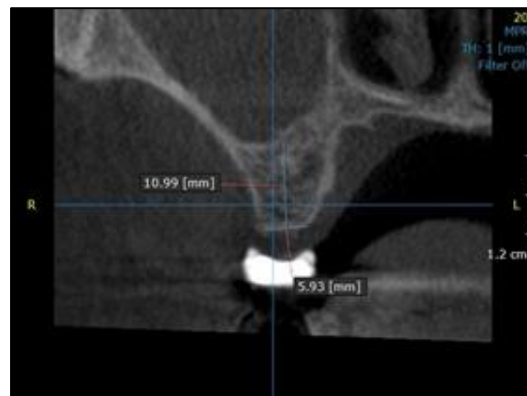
CBCT section of 16
